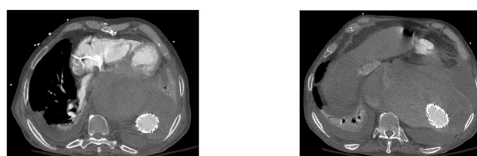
Preoperative computed tomographic angiography demonstrating compression of the left atrium and partial left ventricular compression by the aneurysm.
